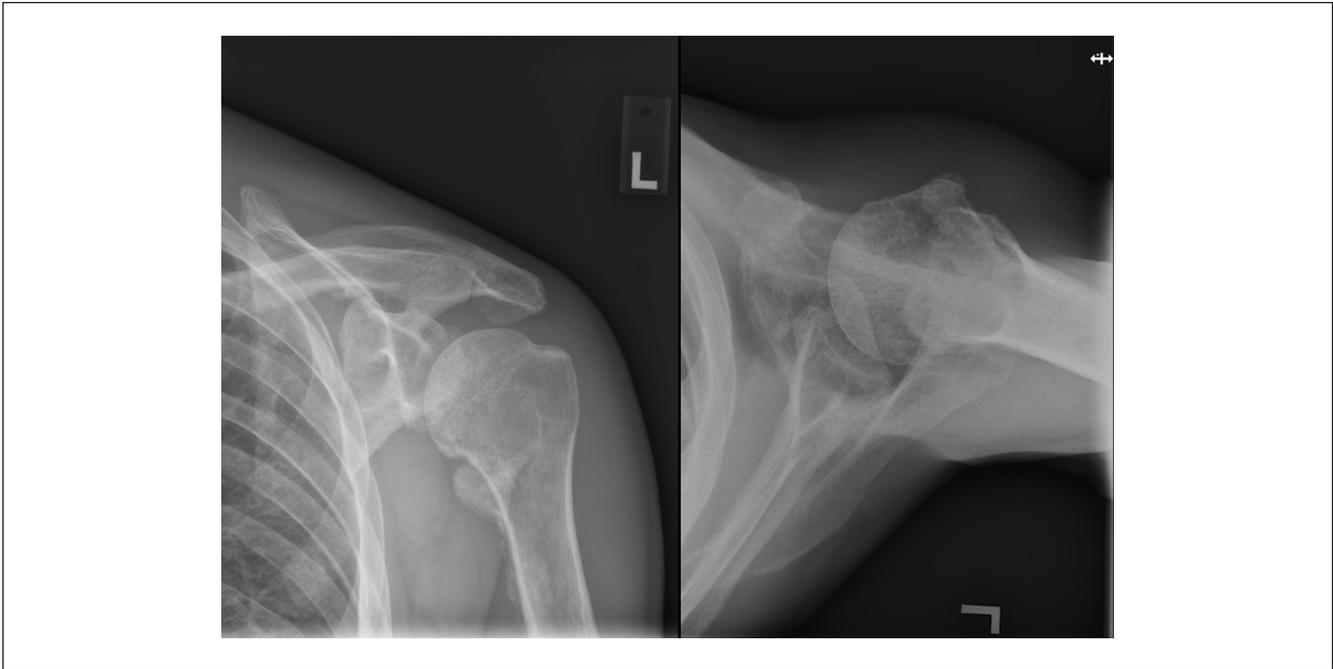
A left shoulder X-ray depicting a mottled appearance of the proximal humeral diaphysis and cortex. Proliferative periosteal bone formation and periostitis can be noted at the glenoid and from the metaphysis to the proximal humeral diaphysis. In addition, there are areas of mild proliferation along the undersurface of the clavicle. Similar findings were noted on the right shoulder.
